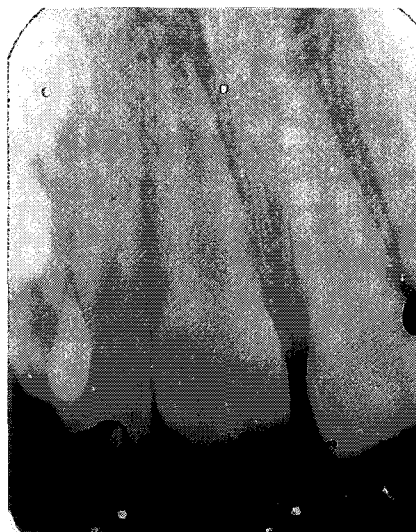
Periapical radiograph of 11, 12 taken immediately after these teeth received an intrusive luxation - 9/1/82.
